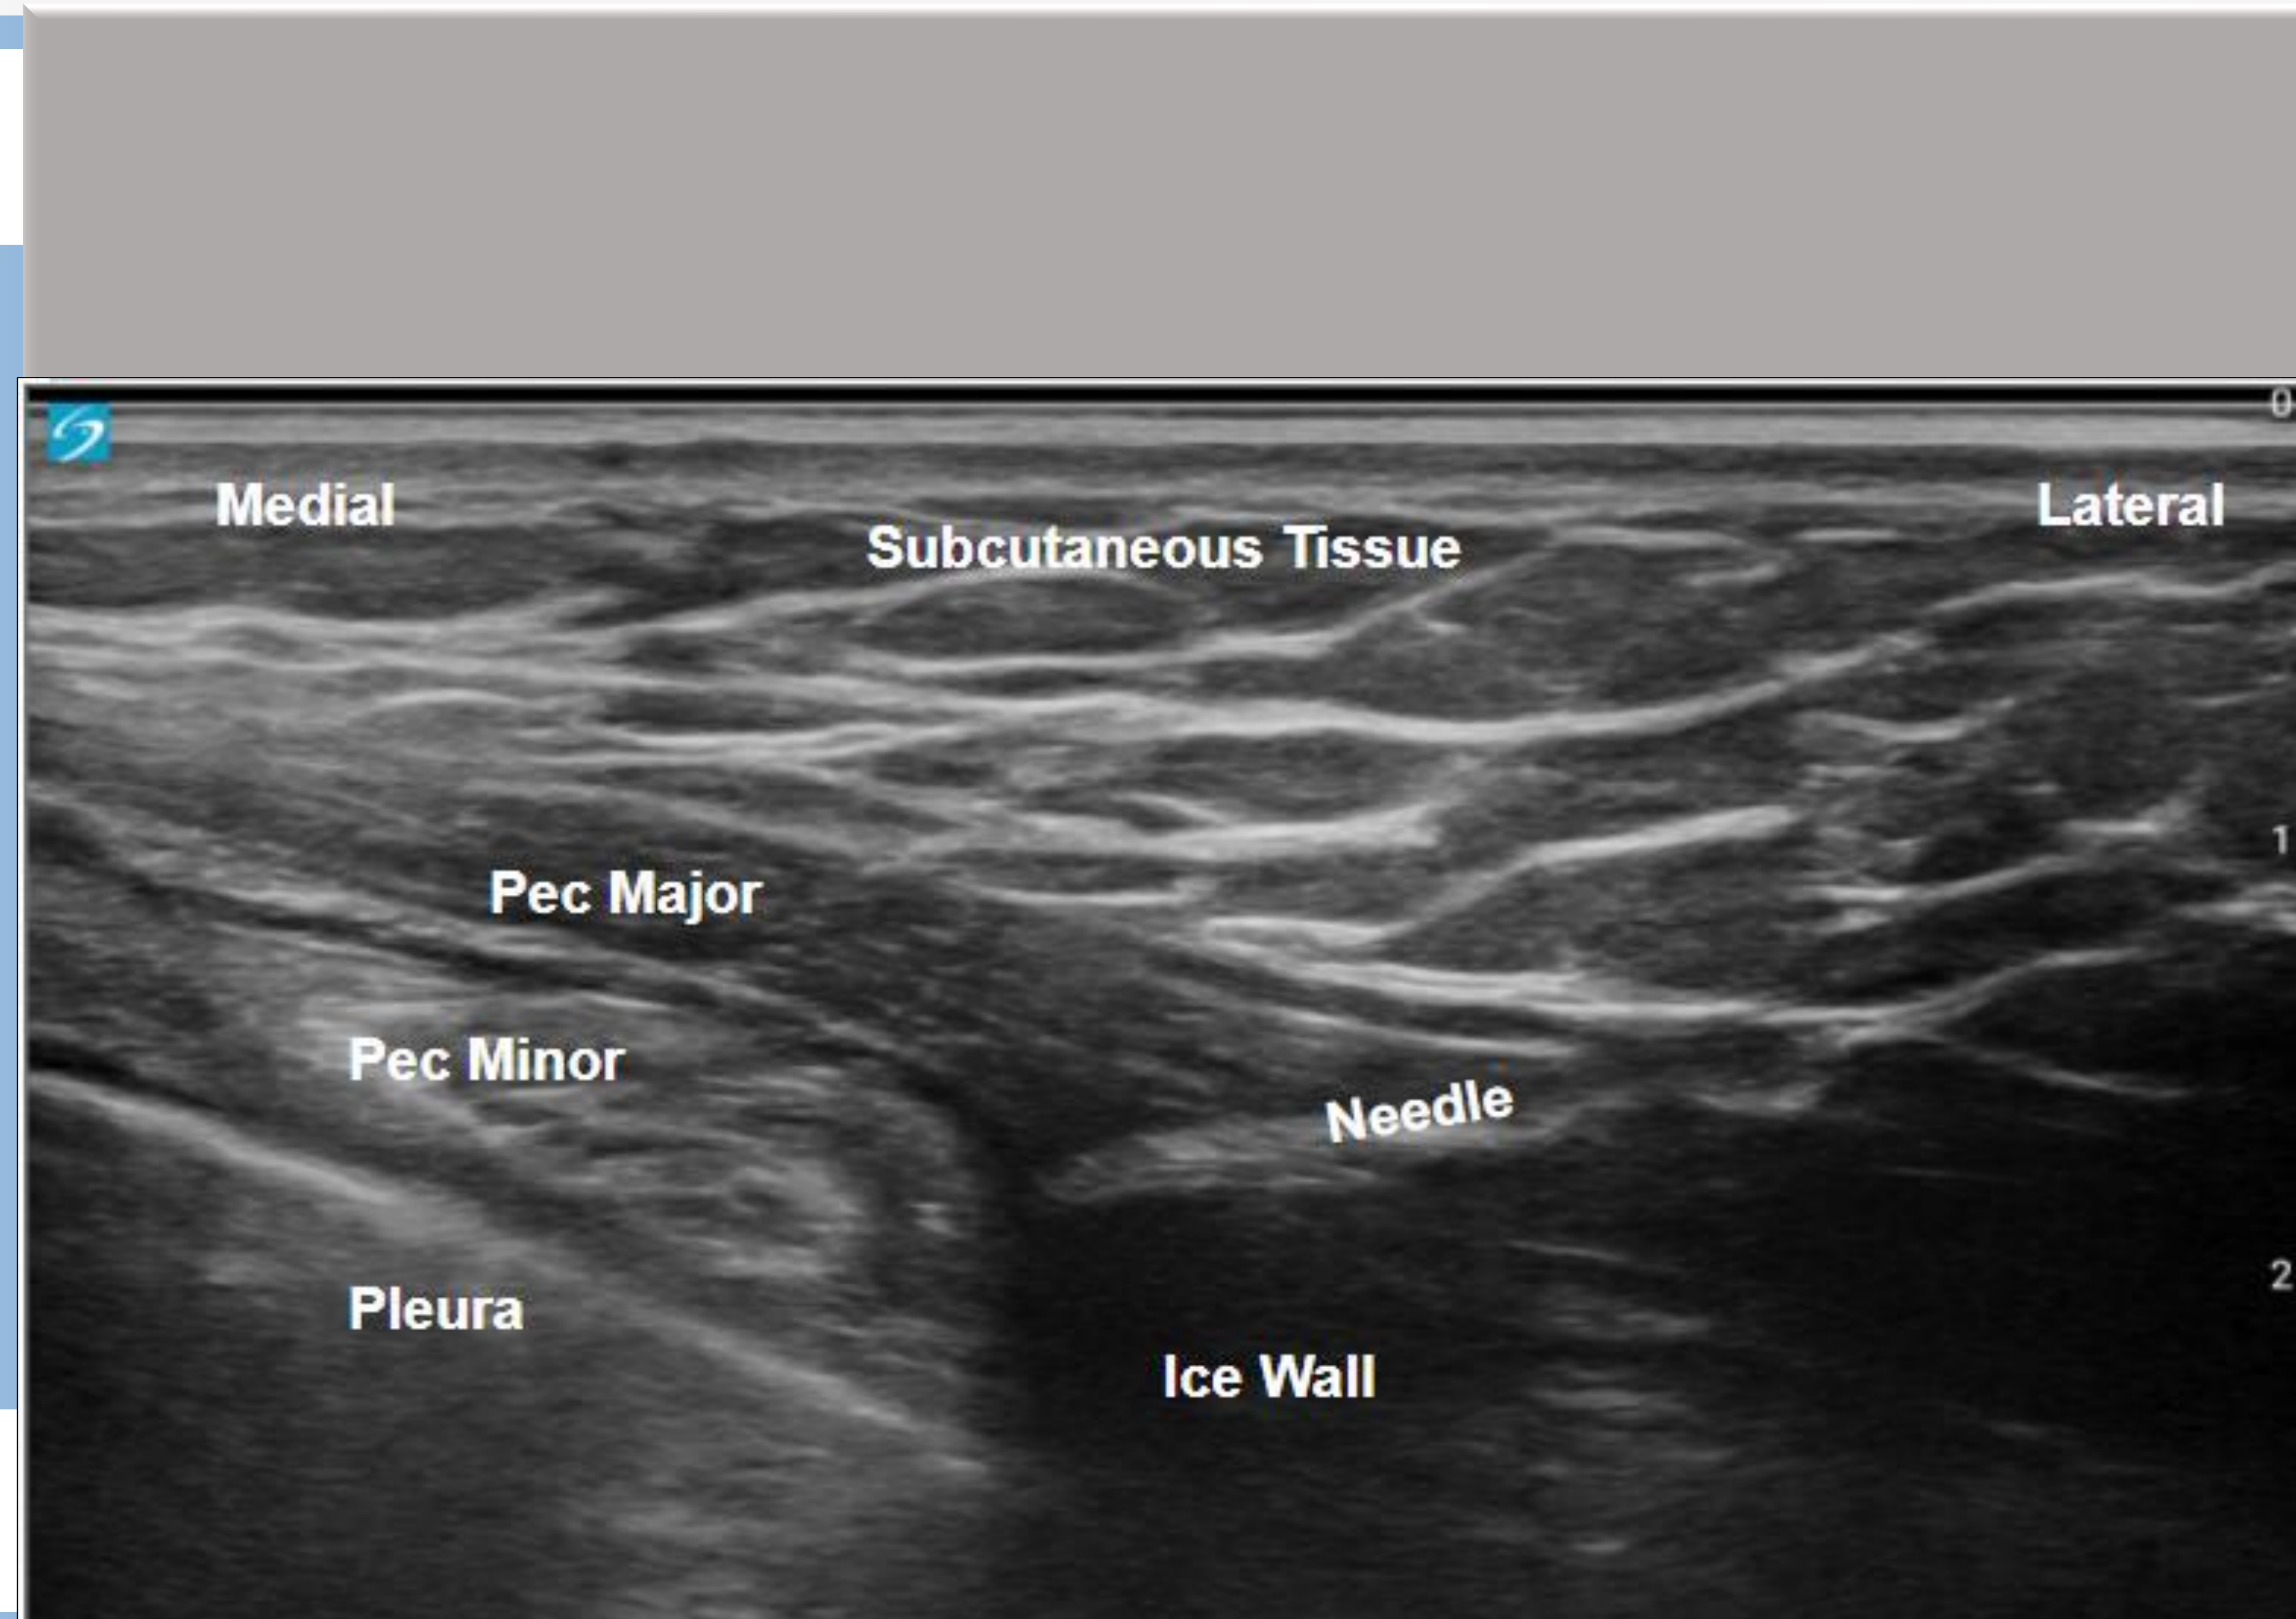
Ultrasound image obtained during cryoneurolysis demonstrating in-plane needle placement between the medial and lateral pectoralis muscles, with formation of the hypoechoic ice ball adjacent to the targeted pectoral nerves.
